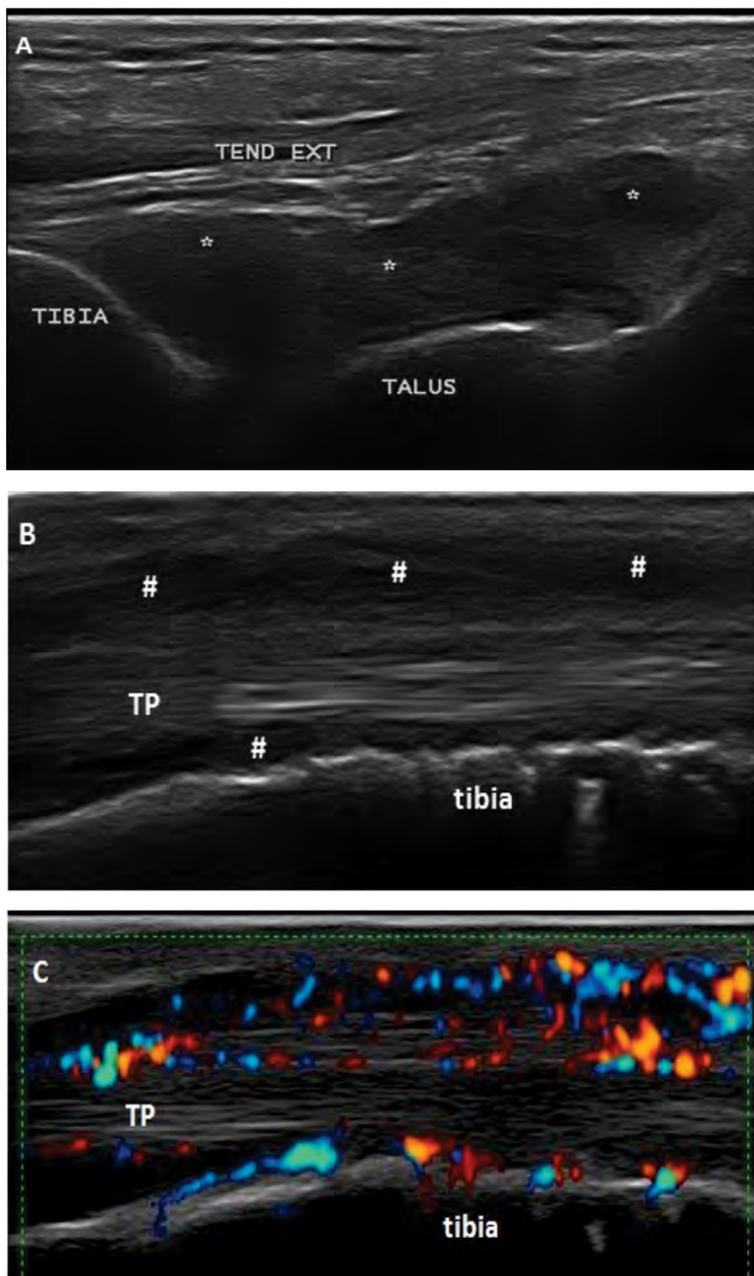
Ankle ultrasound in a rheumatoid arthritis patient in remission: A) dorsal longitudinal scan of the tibiotalar joint, showing distension of the joint capsule by synovial hypertrophy (*); B) longitudinal scan of the tibialis posterior tendon showing B-mode tenosynovitis (# synovial hypertrophy within the tendon sheath); C) power Doppler mode of the tendon from image B, revealing power Doppler signal both within the synovial sheath and also inside the tendon (TP – tibialis posterior tendon).
